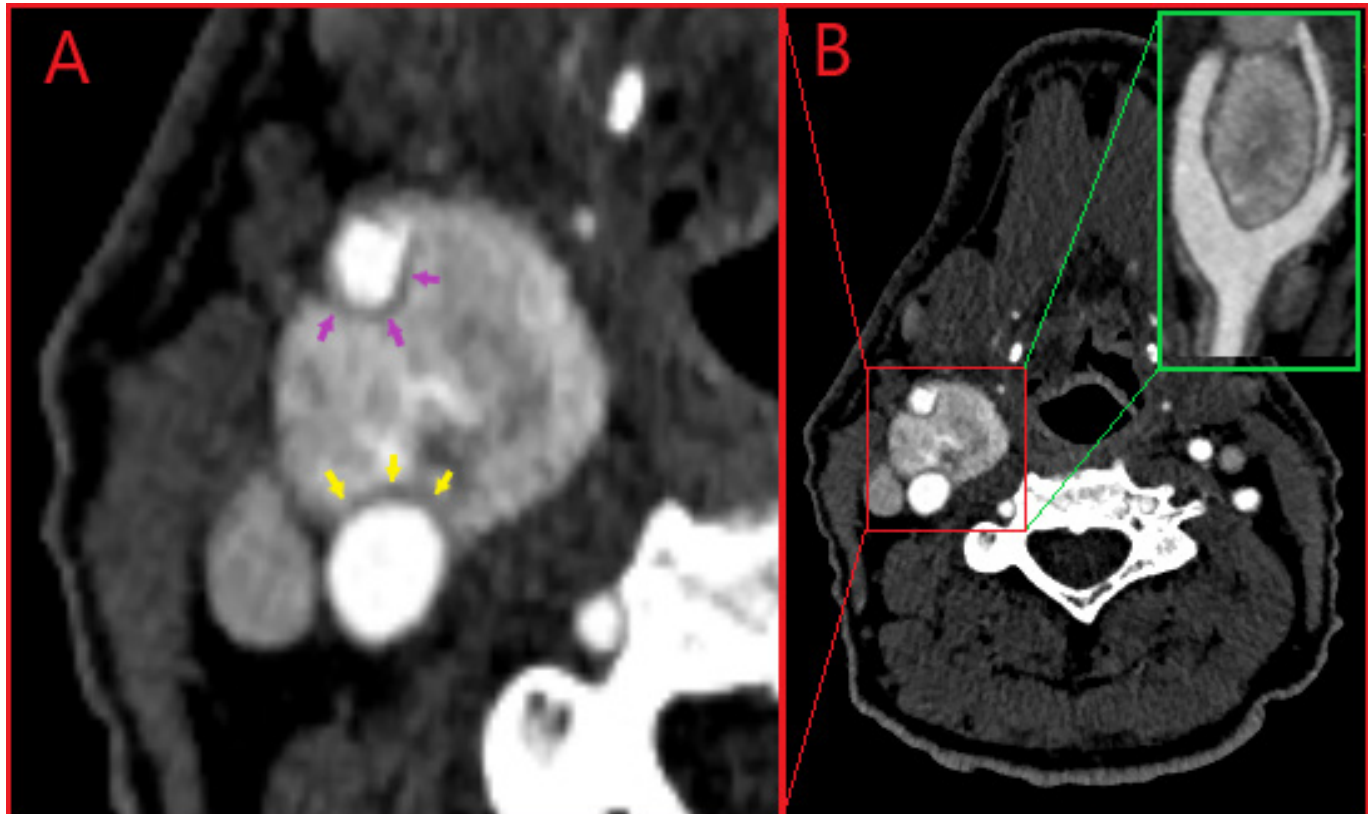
Computed Tomography Angiography (CTA) revealed the presence of a hypodense rim indicating the intact fat plane between the tumor and the adjacent internal carotid artery (A: Purple arrows show the rim around the external carotid artery (ECA) while yellow arrows show the rim around the internal carotid artery (ICA), B: CTA demonstrates the classic 'splaying' of the ICA and ECA.
